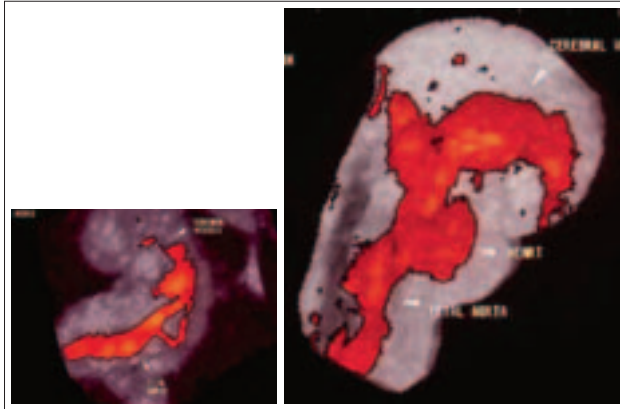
By using recent 3D power Doppler technology, circulatory orientation can be clearly obtained and the common carotid arteries, internal carotid arteries, cerebral arteries visualized. In the eighth weeks of gestation (left image) cerebral vessels are for the first time depicted. Furthermore, vascular anatomy can be seen in increasing details. Note the abdominal aorta with umbilical artery branching at the caudal pole. Umbilical vein can be followed from the abdominal umbilical insertion through the fetal liver and ending below the heart.
